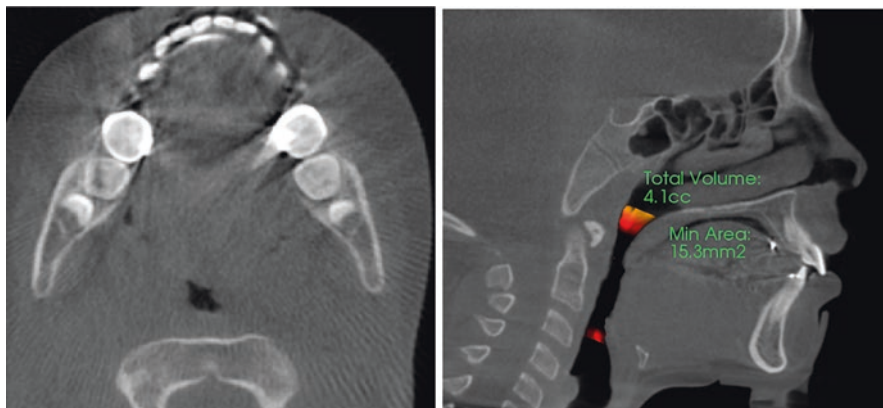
Sagittal CBCT view shows a patient with a forward head posture (chin rest was used on this scan to stabilize the already forward head). The forward head posture may be an attempt to increase oropharyngeal dimensions
